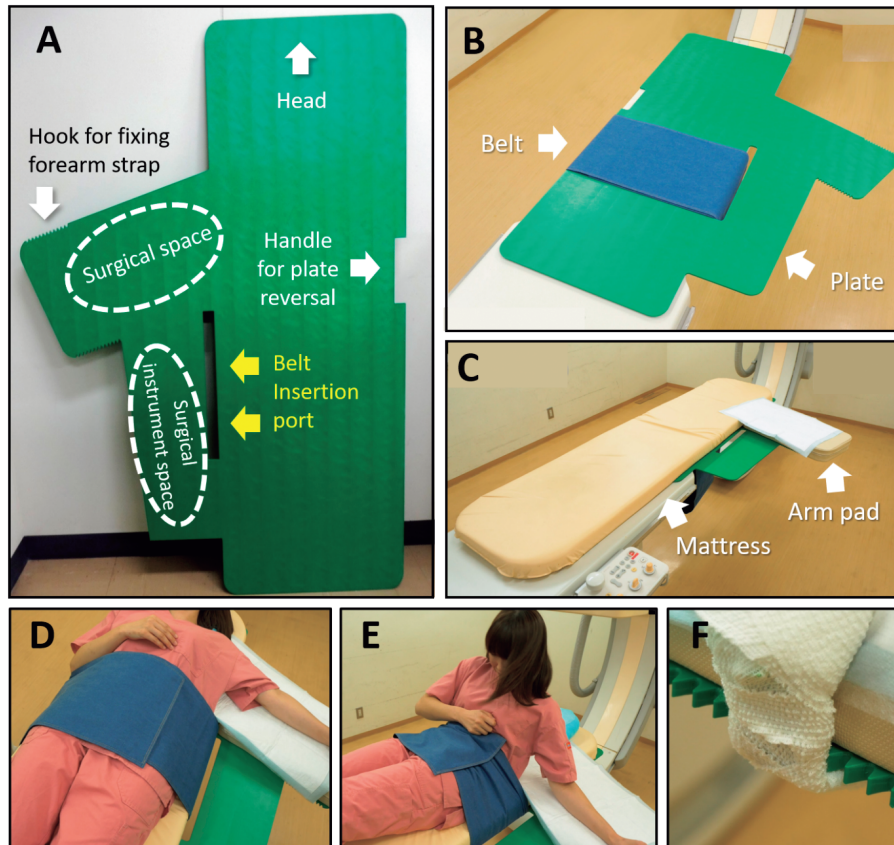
Overview of the vascular-access intervention assisted plate. The plate is designed to have the indicated functions (A). The plate is set on the bed of the X-ray system (B). The mattress and arm stand are set on the plate (C). The patient lies on the mattress and is fixed to the plate and bed by the belt (C). Falls are prevented by fixing the belt at the height of the ilium (D). Serrations are provided for attachment of the forearm-fixing strap (E).
